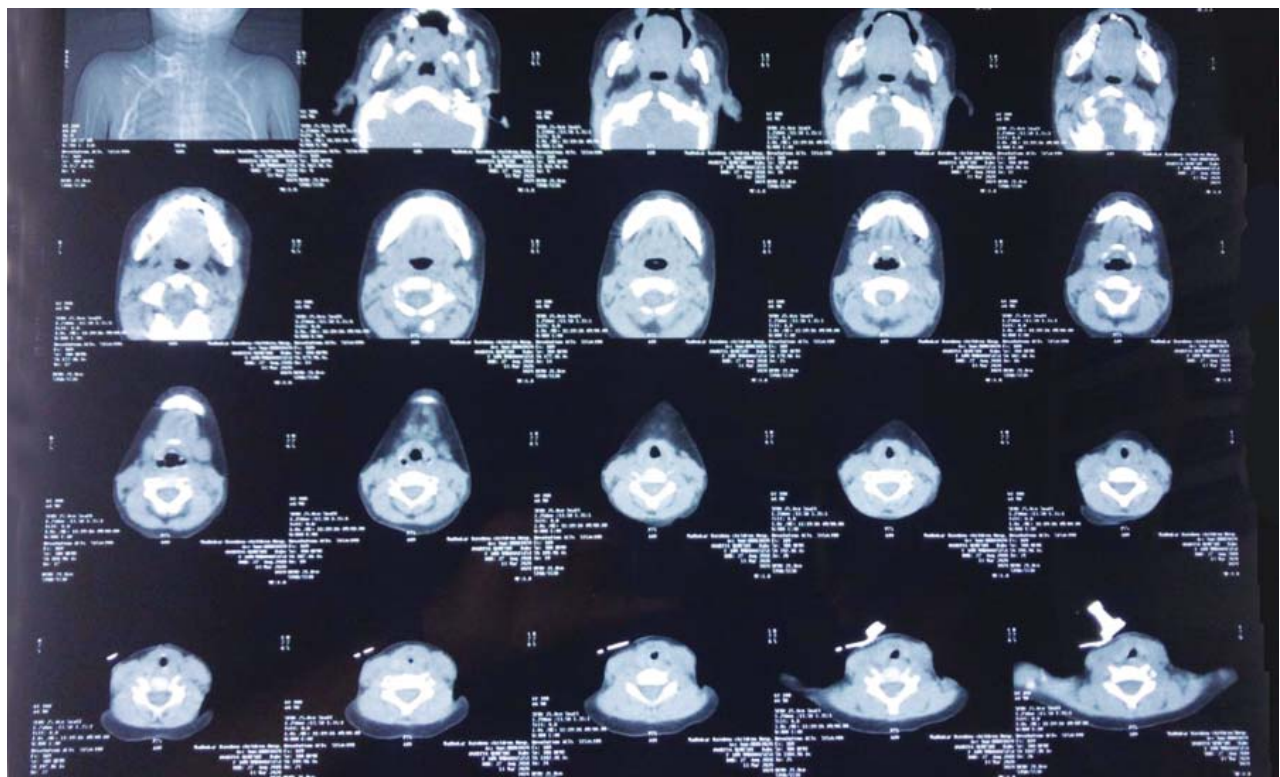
(b): CE CT Neck Airways (Transverse views) post tracheostomy revealing pin hole subglottic lumen
